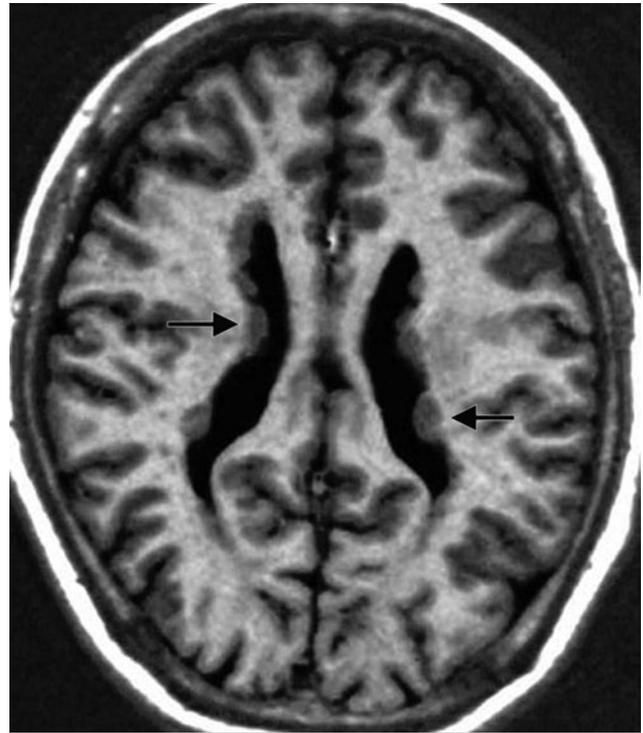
Axial T1-weighted magnetic resonance image of bilateral periventricular nodular heterotopia shows gray matter lining and indenting the lateral ventricles (arrows).
